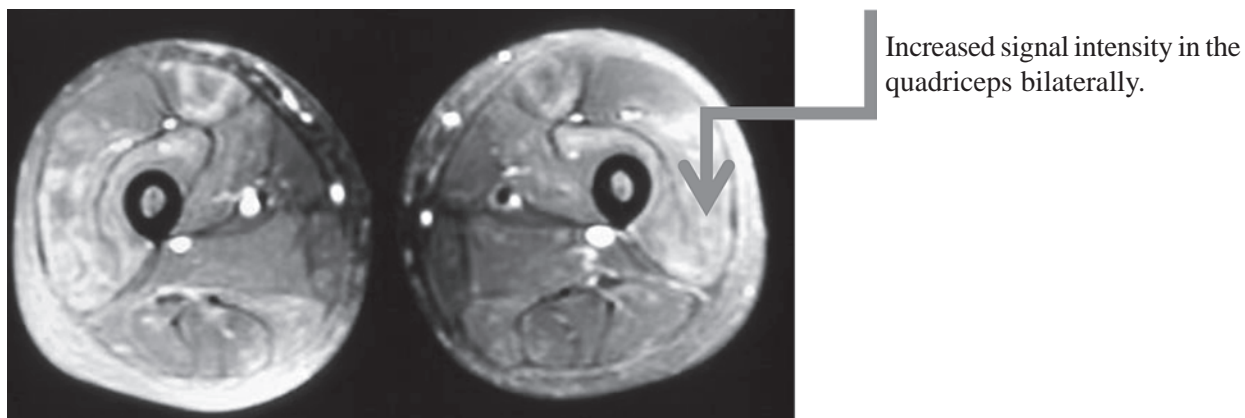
MRI in inflammatory myositis
